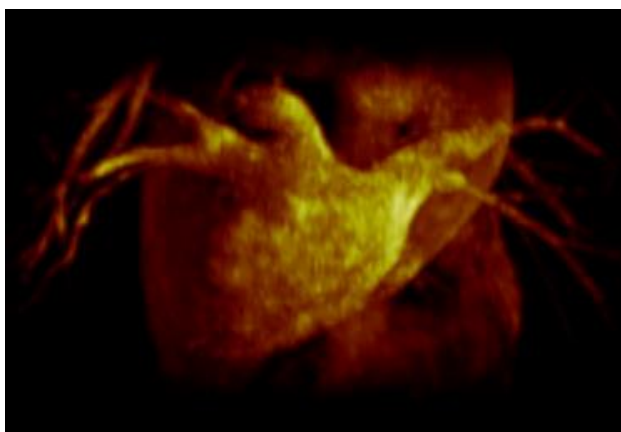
Examples of PVI MRI pictures. Left: angiography; Right: LGE (showing LA fibrosis).
